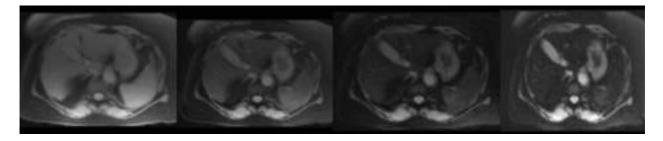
MRI I.5 T (Siemens Avanto), using multi-TE gradient echo T2* MRI technique (using Garbowski method). Liver intensity is normal seen with the longest TE (14.68 msec). T2* =7.4 ms, corresponding to < 5 mg Iron/ g liver dry weight.
